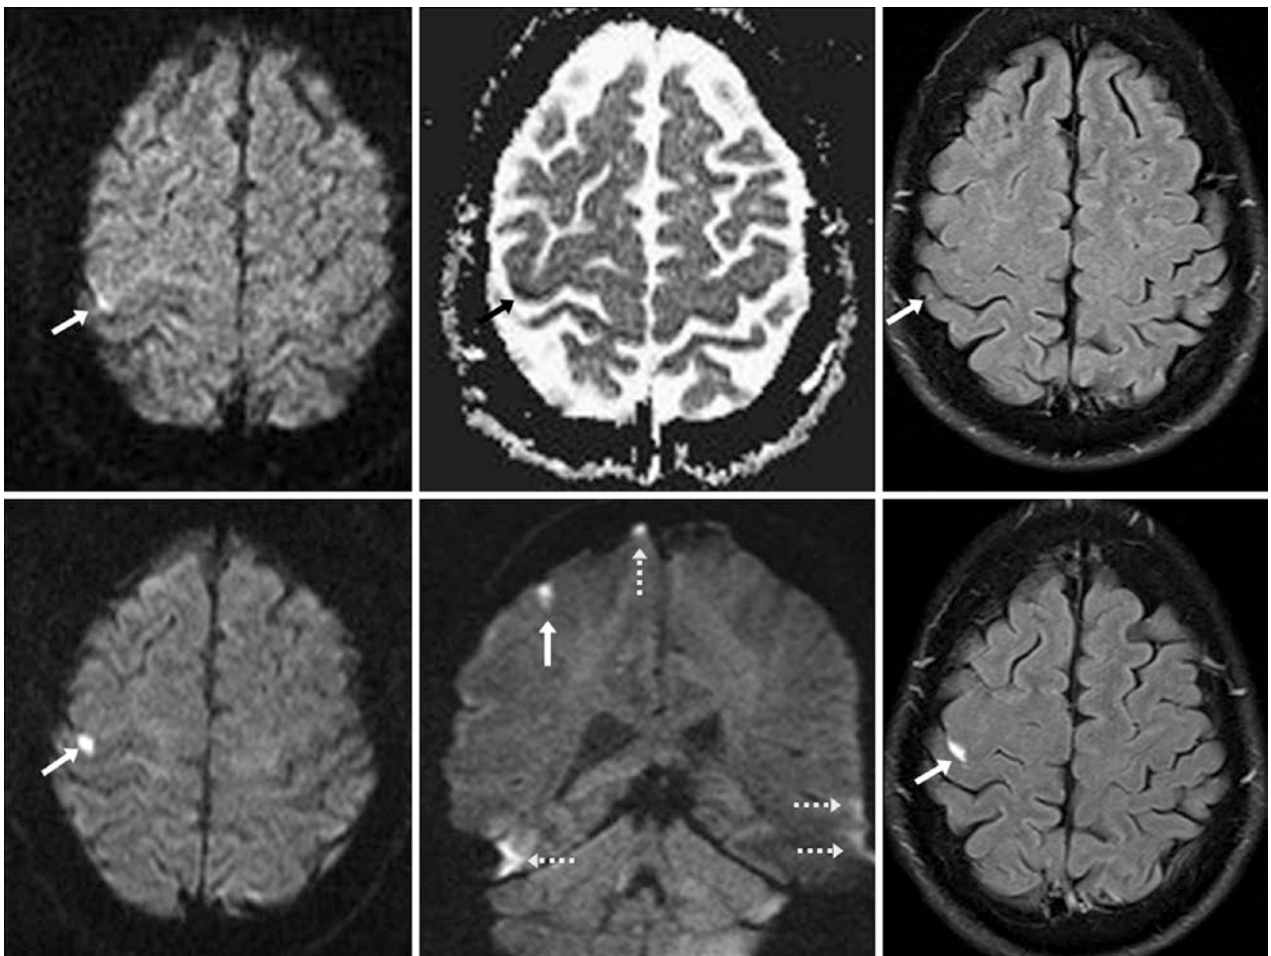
Comparison case of focal cortical infarct. A 44-year-old with acute speech difficulties underwent a 3 T MRI, which showed focal bright signal in the right precentral gyrus (arrows) on DWI MRI (top left), but it was not noticed on an ADC map (top middle) or on FLAIR (top right). It was mistakenly thought to represent susceptibility artifact.
